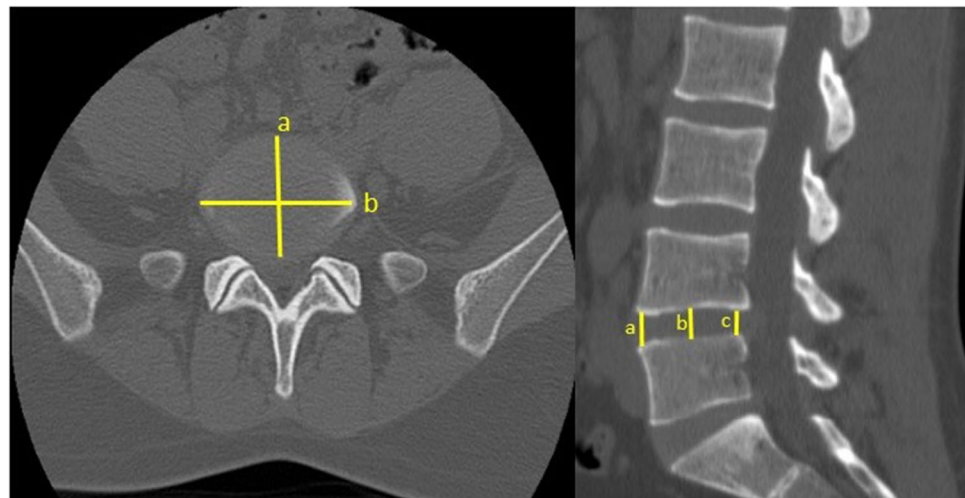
Calculating the disc radius (r) and measuring the intervertebral disc height (h) by reading the CT scans of the lumbar spine in the axial and the sagittal plane
